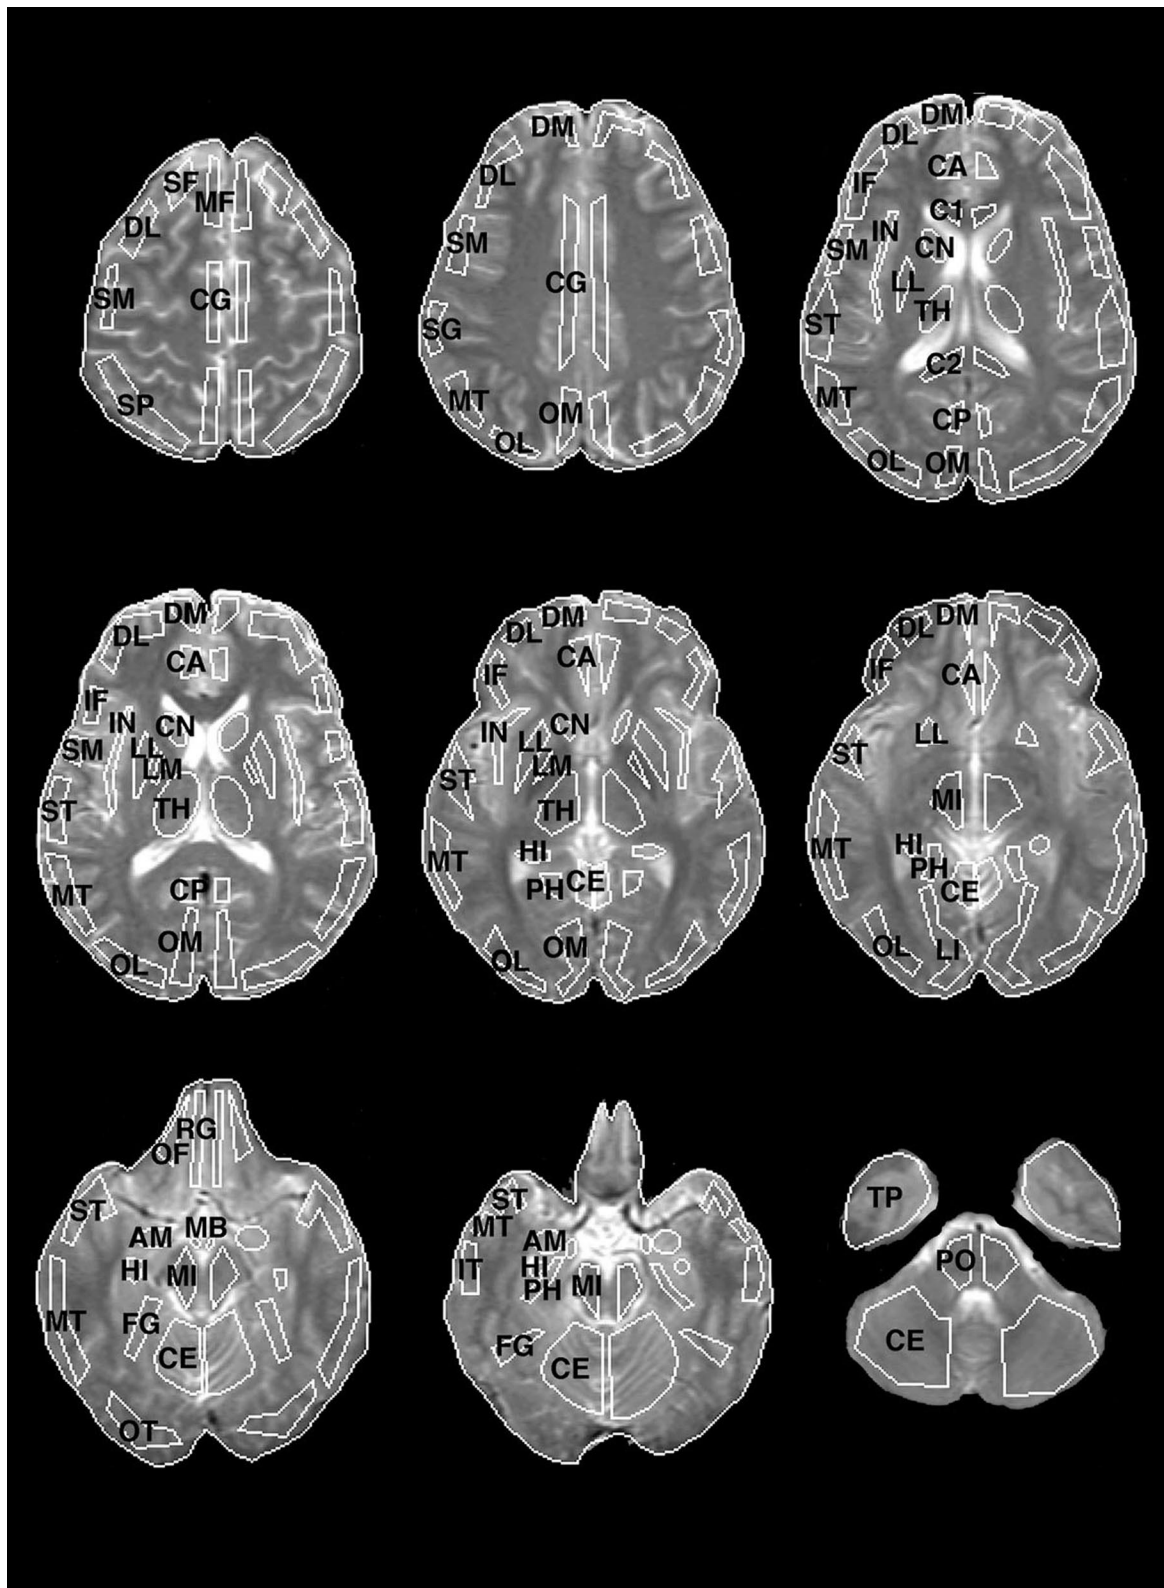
Placement of representative Regions of Interest (ROIs) on MRI images. ROI labels abbreviated as follows: SF=superior frontal, DL=dorsolateral prefrontal, DM=dorsomedial prefrontal, MF=mid-frontal, IF=inferior frontal, SM=sensorimotor, SP=superior parietal, SG=supramarginal gyrus, OM=occipital-medial, OL=occipital-lateral, LI=lingual gyrus, FG=fusiform gyrus, OT=occipitotemporal, ST=superior temporal, MT=mid-temporal, IT=inferior temporal, TP=temporal pole, PH=parahippocampal gyrus, HI=hippocampus, AM=amygdala, IN=insula, OF=orbital frontal, RG=rectal gyrus, CA=cingulate gyrus-anterior, CG=cingulate gyrus, CP=cingulate gyrus-posterior, C1=corpus callosum-anterior, C2=corpus callosum-posterior, CN=caudate nucleus, LM=lenticular-medial [globus pallidus], LL=lenticula-lateral [putamen], MB=mammillary body, TH=thalamus, MI=midbrain, PO=pons, CE=cerebellum. Regions included in the analysis are in bold.
